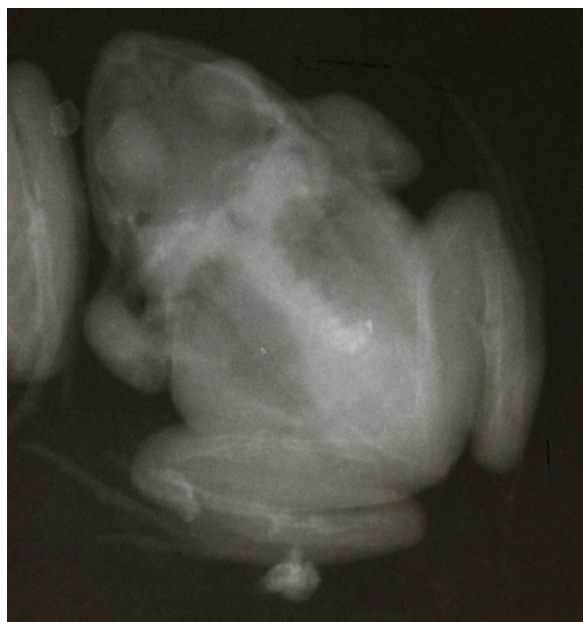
Radiograph of a 5-month-old captive bred mountain chicken (*Leptodactylus fallax*) at Durrell Wildlife Conservation Trust raised without UV-B radiation exhibiting metabolic bone disease.
